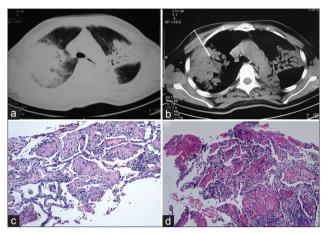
Patient 1, female, 52 years old. Cough, sputum, and fever for more than 20 days. Computerized tomography scan showed bilateral lobar consolidation; (a) Lung window; (b) Mediastinal window; (c) The patient was confirmed to have acute fibrinous and organizing pneumonia by using transthoracic needle biopsy; (d) Three days later, the same patient was confirmed to have the same pathological diagnosis of acute fibrinous and organizing pneumonia using transbronchial lung biopsy.
